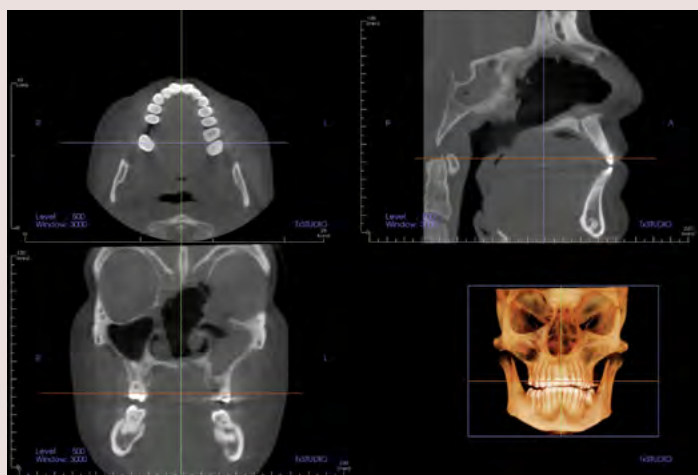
Images derived from CBCT demonstrating oronasal communication and absence of septum.
